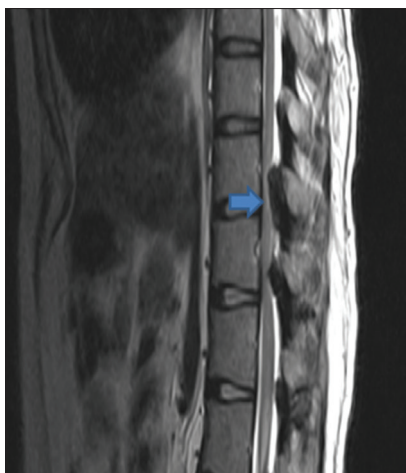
T2-weighted sagittal section at T10-T11 level showing ossification of ligamentum flavum with severe spinal canal stenosis and cord compression (arrow)
